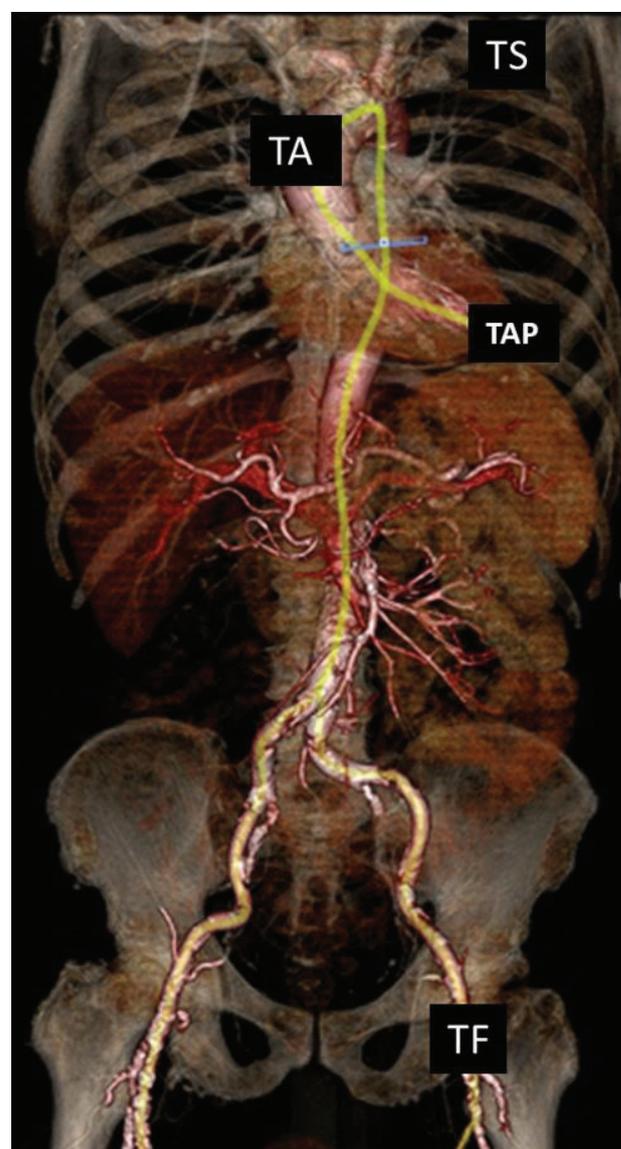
The potential entry sites are demonstrated on the 3D CT image: transfemoral (TF), trans subclavian (TS), transaortic (TA), and transapical (TAP).
